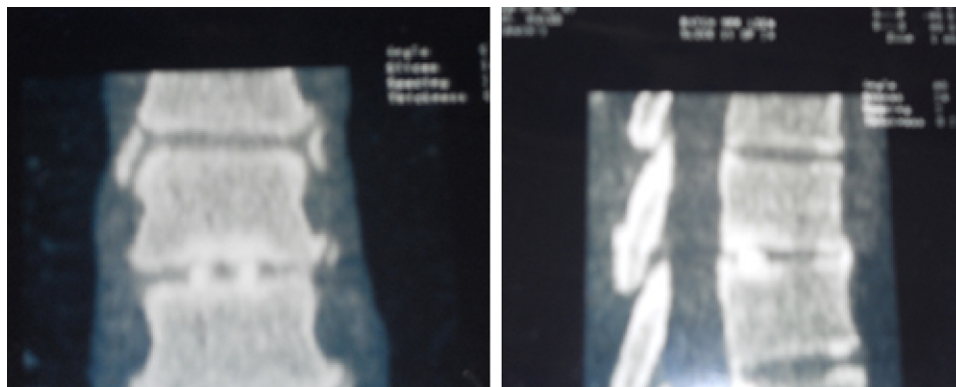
4 months post-operative CT Scan of interbody fusion of the thoracic spine.
